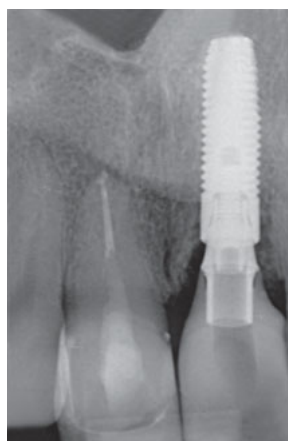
Radiograph of the final restorations 1 year after delivery.
